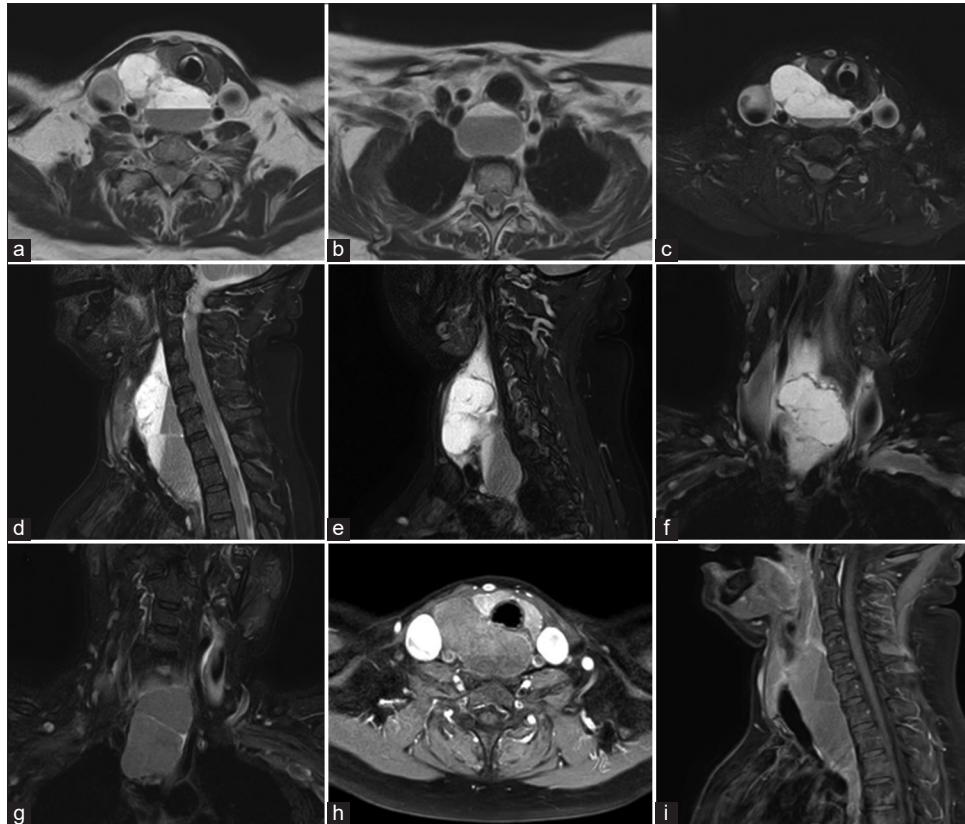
Axial T2-weighted (a and b) and fat-saturated images (c) of lower neck and upper mediastinum reveals a multiloculated T2 hyperintense lesion with blood-fluid levels which is posterior to the right lobe of thyroid and extending to superior mediastinum. T2 fat sat sagittal (d and e) and coronal (f and g) images shows the craniocaudal extent of the lesion with clear demonstration of the internal hemorrhage. T1 post-contrast axial (h) and sagittal (i) sections show peripheral rim of enhancement and clear demonstration of the relationship to the right lobe of thyroid.
